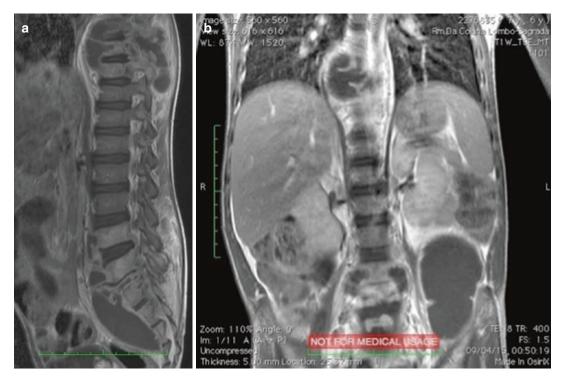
Sagittal (a) and coronal; (b) T1-weighted MRI after gadolinium injection showing noncontiguous spinal TB with multiple thoracic left iliopsoas and pre-lumbosacral abscess with characteristic thick walls
